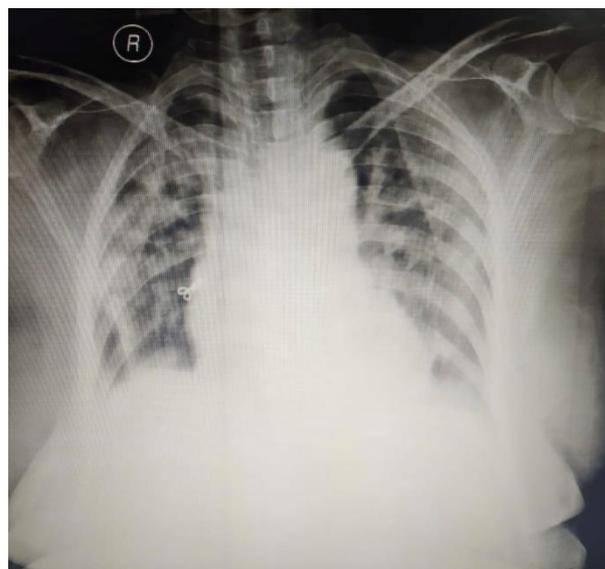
Chest X-ray PA view showing bilateral mid and lower zone infiltrates predominantly involving peripheral fields.
